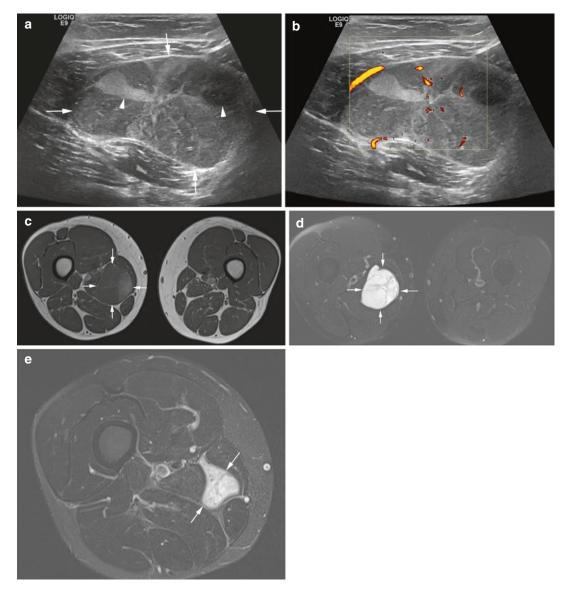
(a–e) Myxoid liposarcoma of the right thigh. (a) Ultrasound. (b) Ultrasound with Doppler. (c) Coronal fat-suppressed SE T2-weighted MR image. (c) Axial SE T1-weighted MR image. (d) Axial FS TSE T2-weighted MR image. The mass lies in the medial compartment displacing gracilis and the neurovascular bundle. On ultrasound the mass
